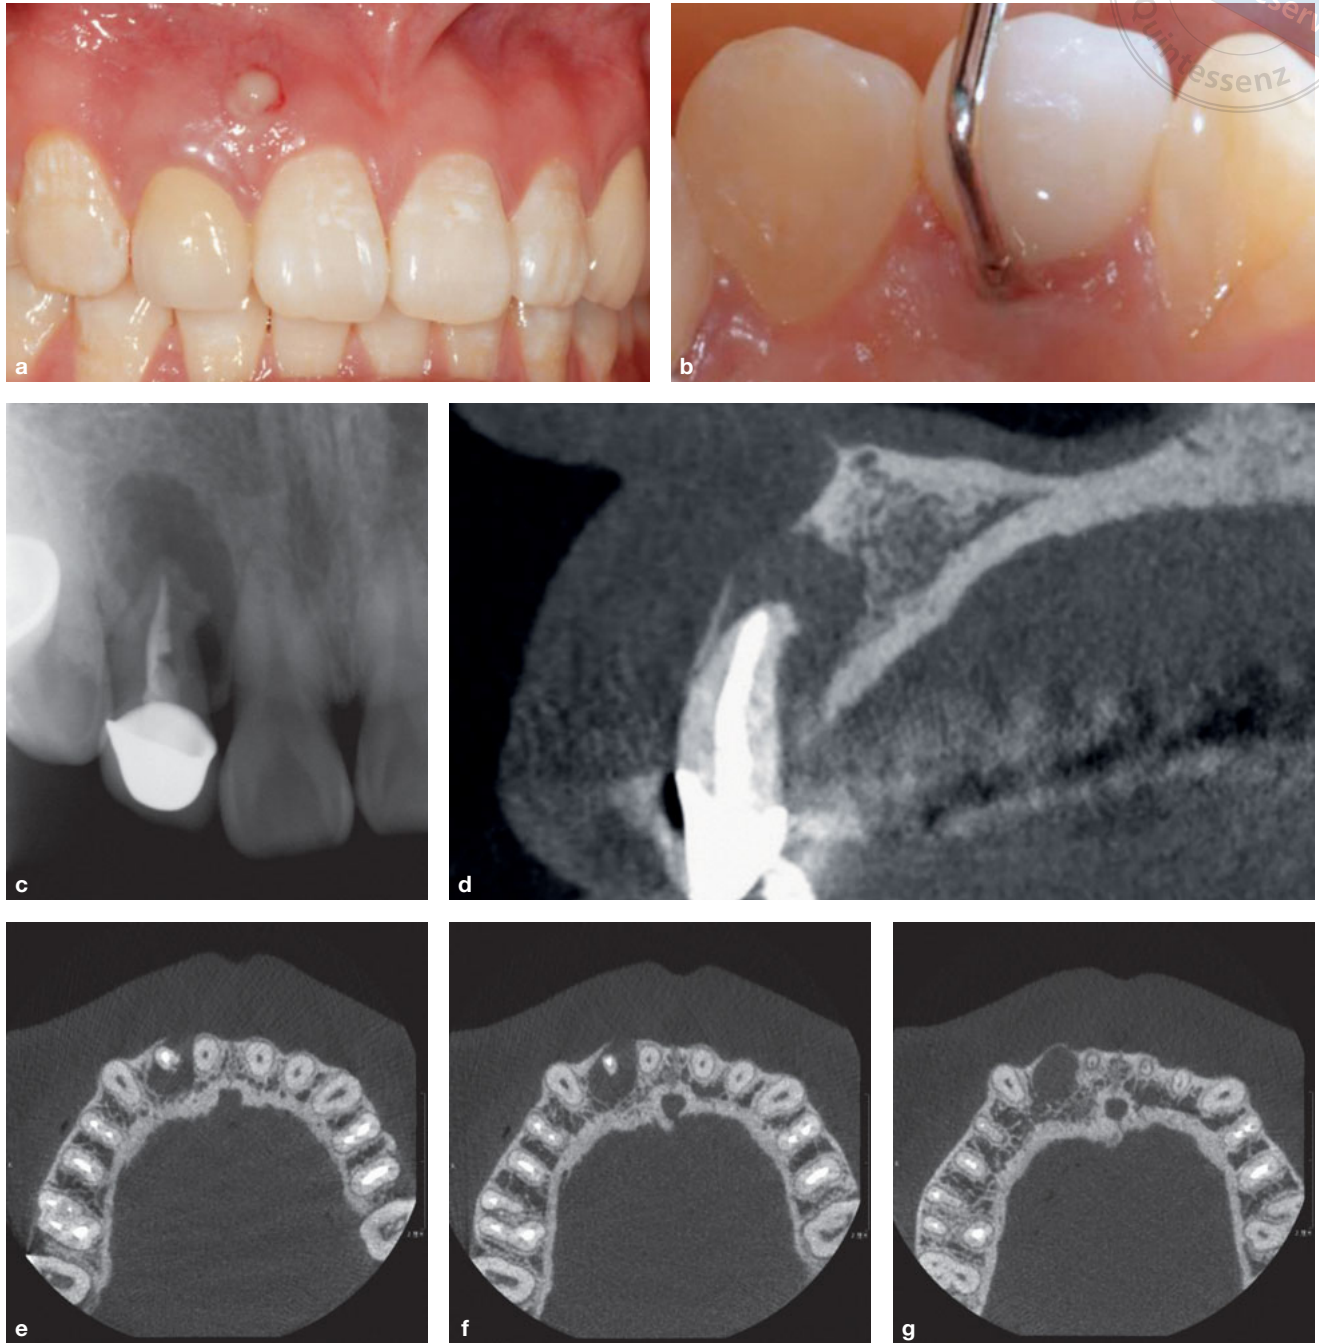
(a) The maxillary right lateral incisor. The preoperative clinical photograph shows a draining sinus tract on the labial gingiva. (b) A palatogingival groove was detected on the maxillary right lateral incisor, accompanied by a 9-mm periodontal pocket in the mid-palatal region. (c) On radiographs, an extensive periradicular radiolucency was associated with the affected tooth. (d)–(g) A serious bone defect was observed around the tooth with CBCT. The prognosis of the tooth was considered to be very poor.
